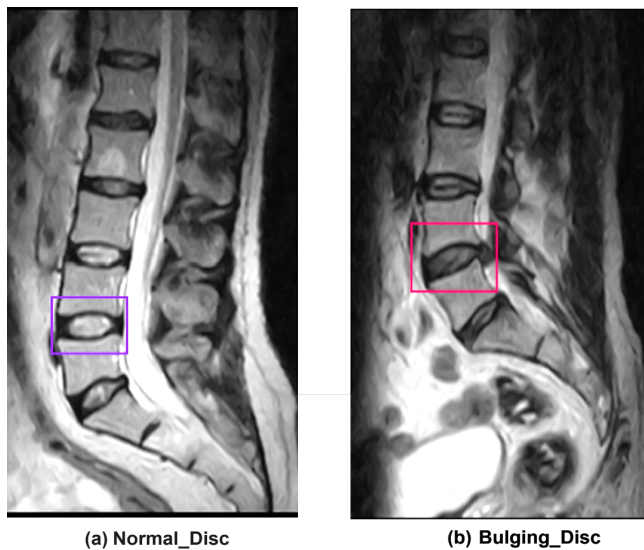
e.g. MRI image of Normal and Bulging disc.
